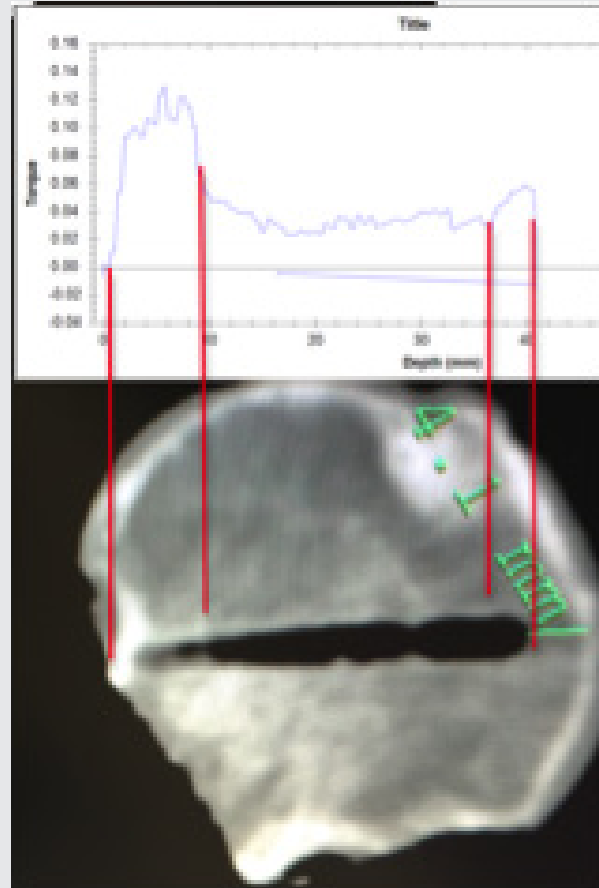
GUI and CT from human hip using VDC 3D awareness to drill up to the edge (less than 5 mm) of the hip without fluoroscopy. Near cortex torque measured at 0.12 Newton meters, decision to stop drilling when 50% of that torque was re-obtained produced the desired result in each of three hips.
